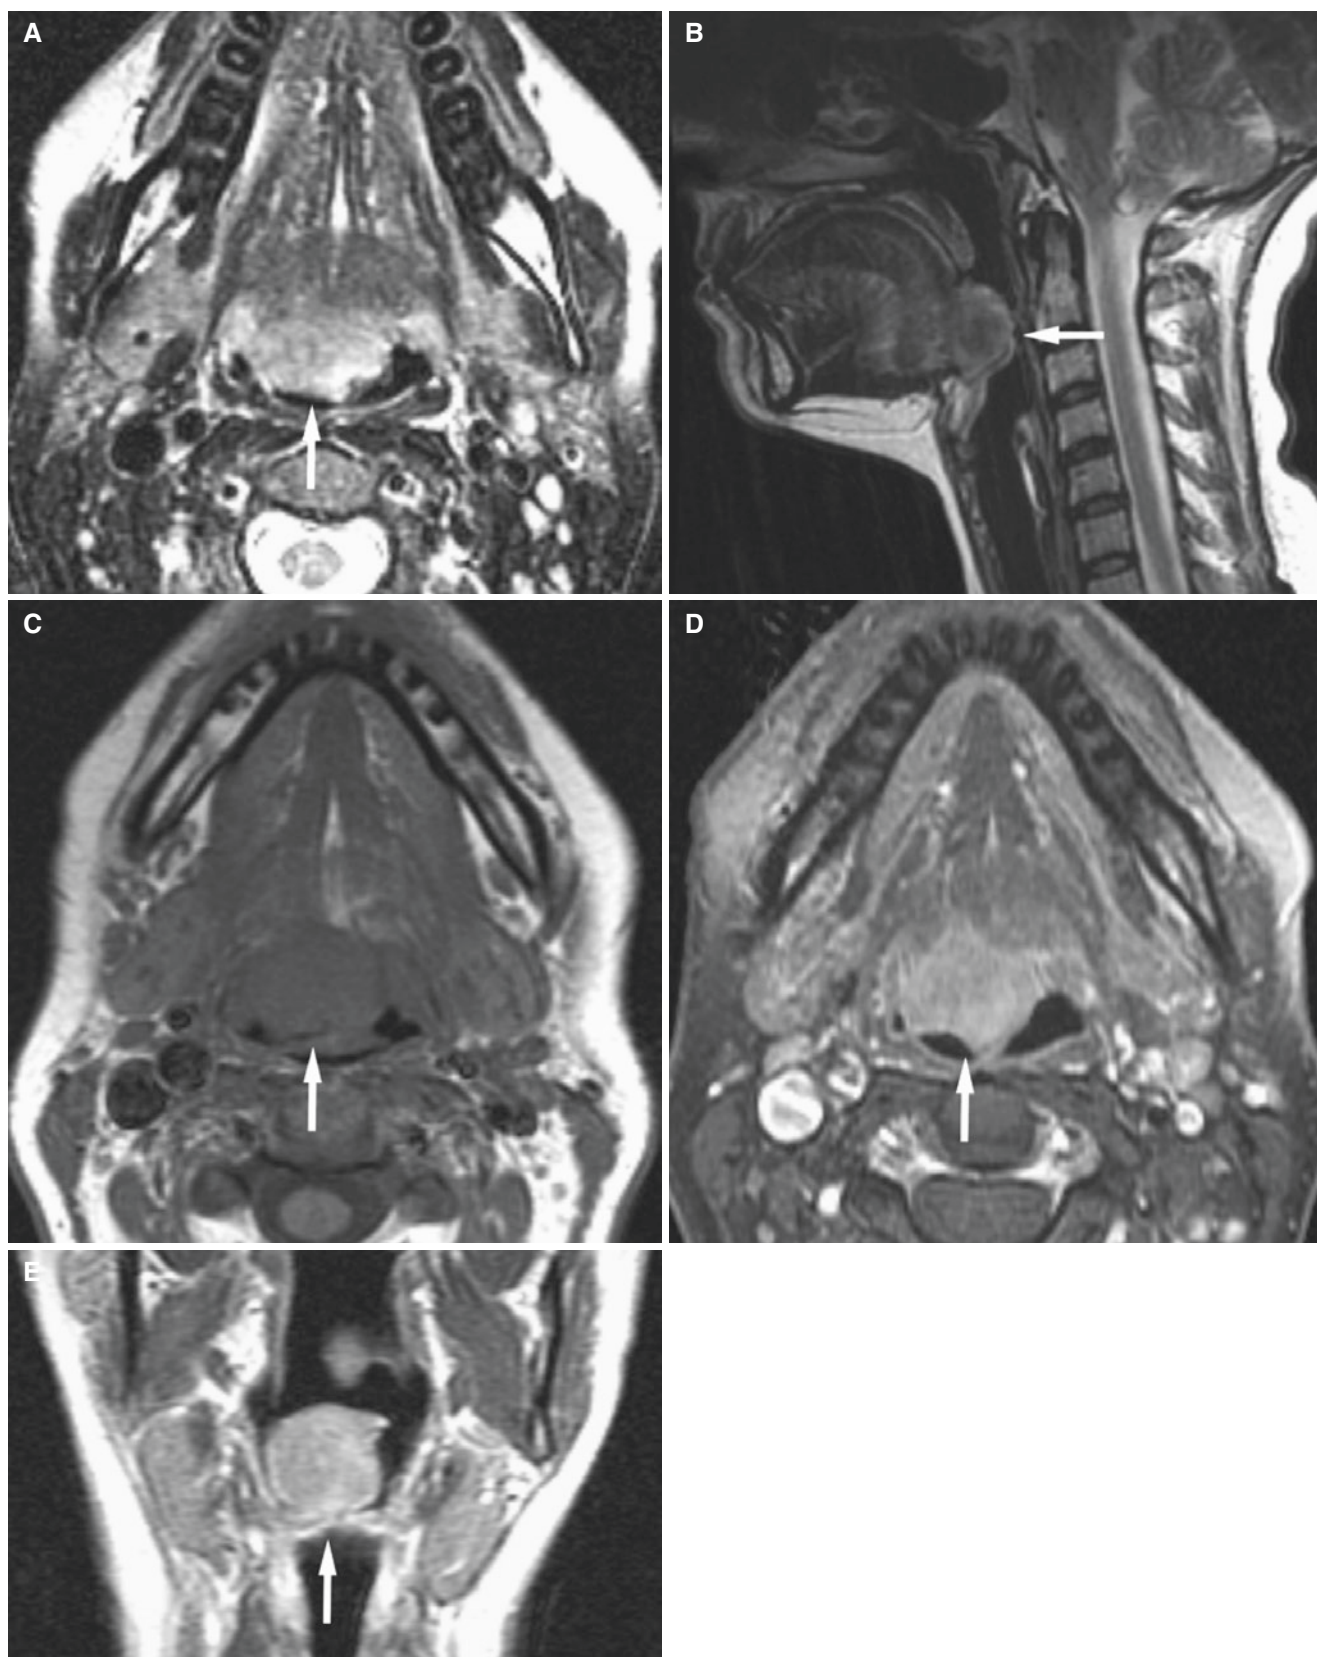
Clear-cell carcinoma of tongue base; 47-year-old female with hemoptysis, presents with lump in vallecula, “vascular granuloma” clinically. (A) Axial T2-weighted MRI shows heterogeneous high-signal mass in posterior portion of tongue (*arrow*). (B) Sagittal T2-weighted MRI shows mass in tongue base (*arrow*). (C) Axial
